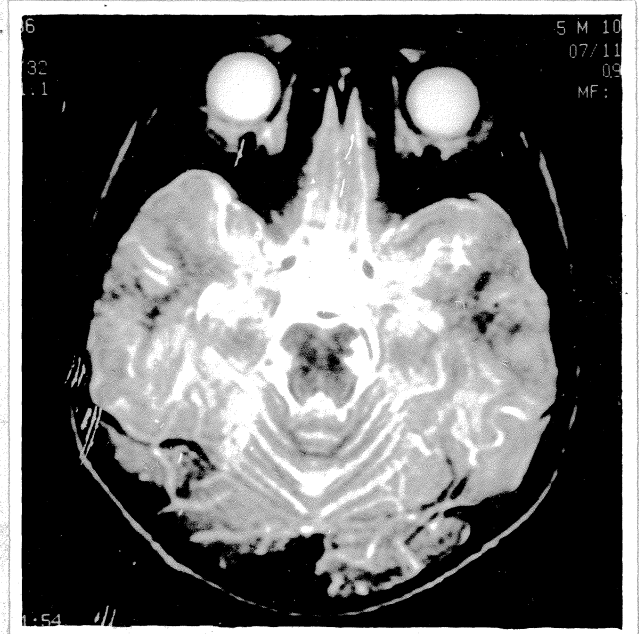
Brain stem section showing lateral pontine involvement in ALD (MRI T₂ WI).
